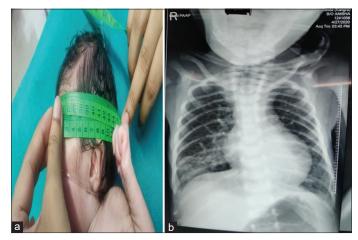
(a) Microcephaly; (b) chest X-ray of newborn showing the right lower lobe consolidation with pneumonia and cardiomegaly
